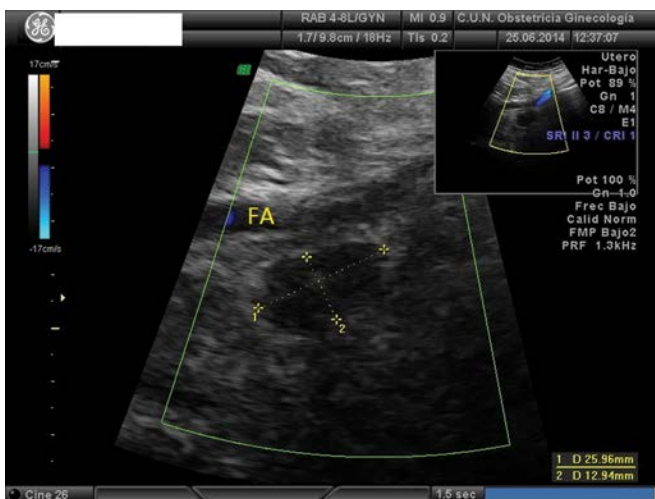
Inguinal ultrasound in a case of vulvar carcinoma. A suspicious lymph node can be detected behind the femoral artery.
